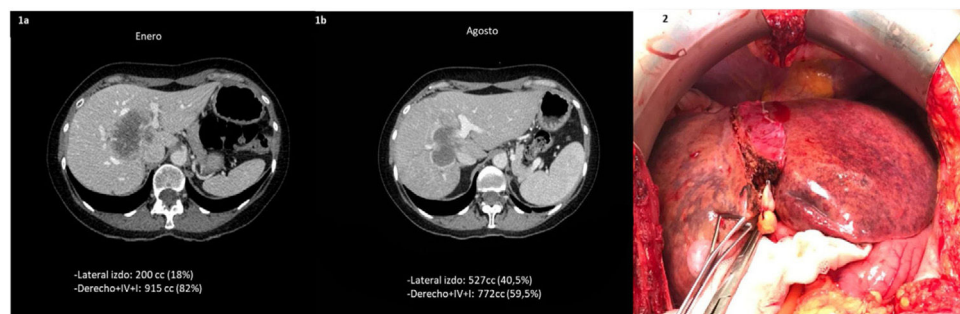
(1) Progress after neoadjuvant treatment. (1a) Venous phase of initial CT scan, prior to treatment: large hypodense mass in central position in direct contact with the middle hepatic vein. (1b) Post-embolization CT scan: significant contralateral hypertrophy (S II–III). (2) Surgical intervention: right hepatic atrophy and contralateral hypertrophy, of segments II–III.
